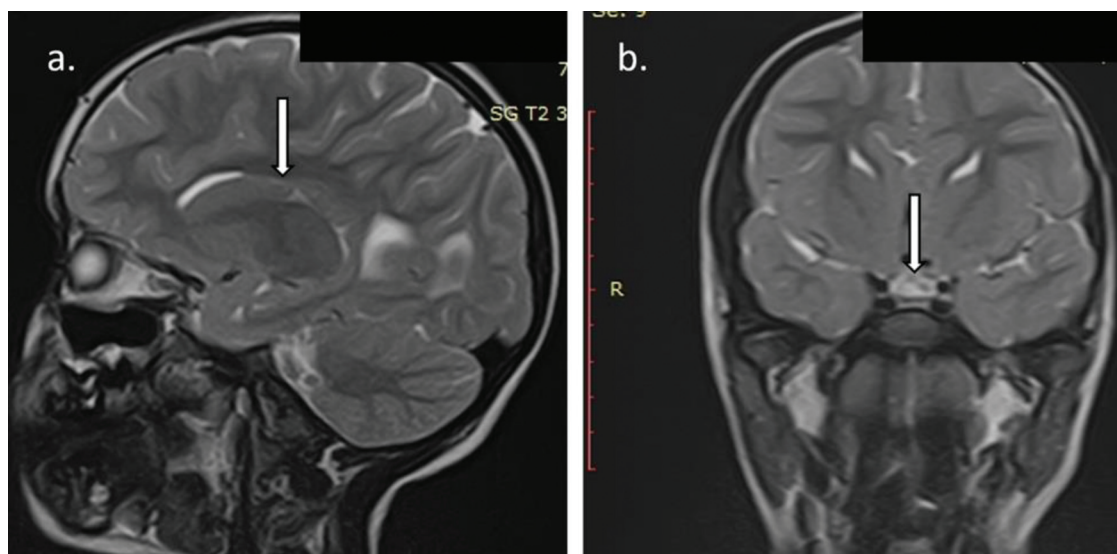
Brain MRI revealing agenesis of the corpus callosum (a.) and pituitary hypoplasia (b.).
